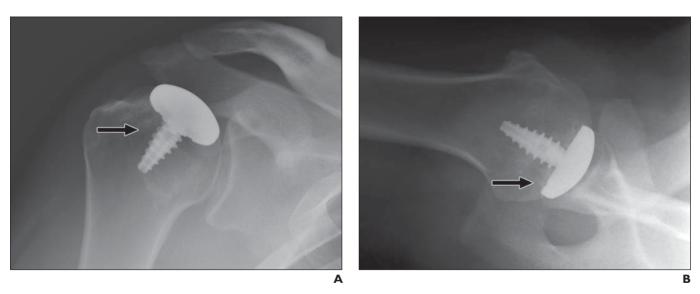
31-year-old man who underwent arthroplasty of right shoulder for chondral defect related to previous dislocations. A and B, Anteroposterior (A) and axillary (B) radiographs show partial resurfacing arthroplasty (arrow).
